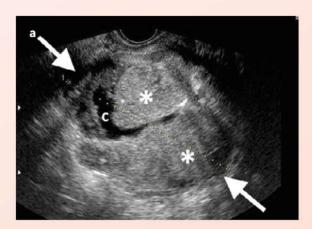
a. US showing an ovarian mass that is mostly solid (*) with cystic component (c) in a pre-menopausal woman; solid components were vascular on Colour Doppler US (not shown here). b. Sagittal T2-weighted MR image in a different post-menopausal patient showing a large complex ovarian mass (arrows) above the bladder (arrowhead). Both lesions a and b were confirmed to be ovarian cancers.
